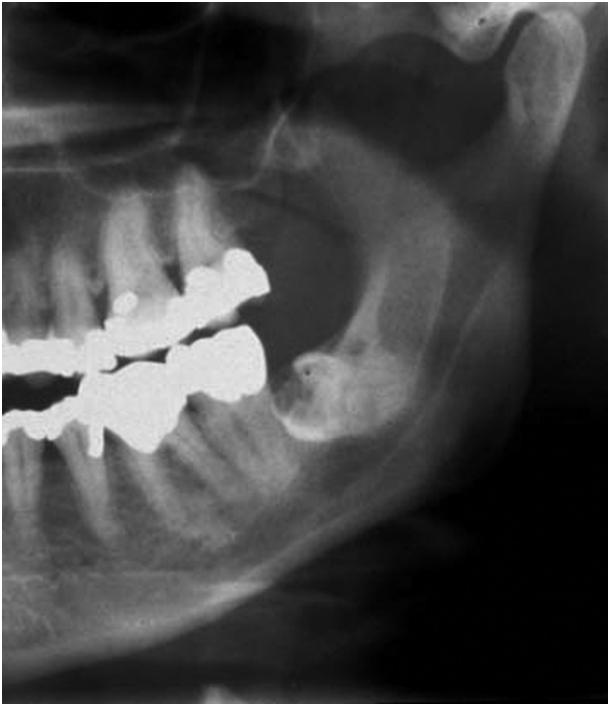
Part of panoramic radiograph with semiretained lower left third molar with resorption in the crown.
